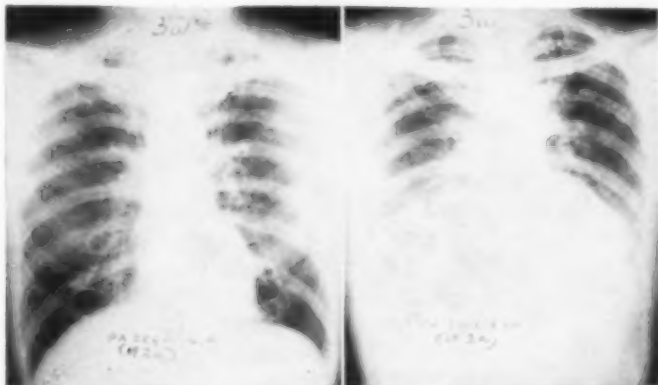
X-ray films taken in upright position of the same persons, show normal diaphragmatic excursion.
